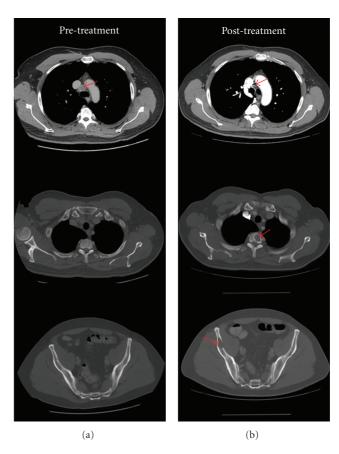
Patient with partial response in lymph nodes but progression in bone. CT scans before (a) and after (b) 6 months of therapy with a TKI. The patient had a partial response in mediastinal and hilar adenopathy but progression in bone with cortical destruction. The patient's bone lesions were irradiated, and he was restarted on the TKI. The patient continues on the TKI after 24 months and has no further evidence of progression.
